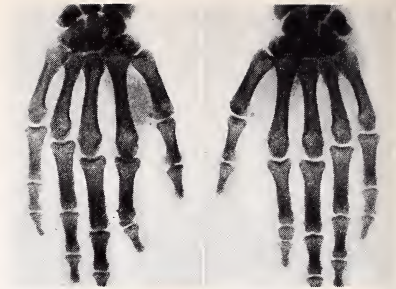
Radiographs of the type of brachyphalangy shown in Fig. 5.
